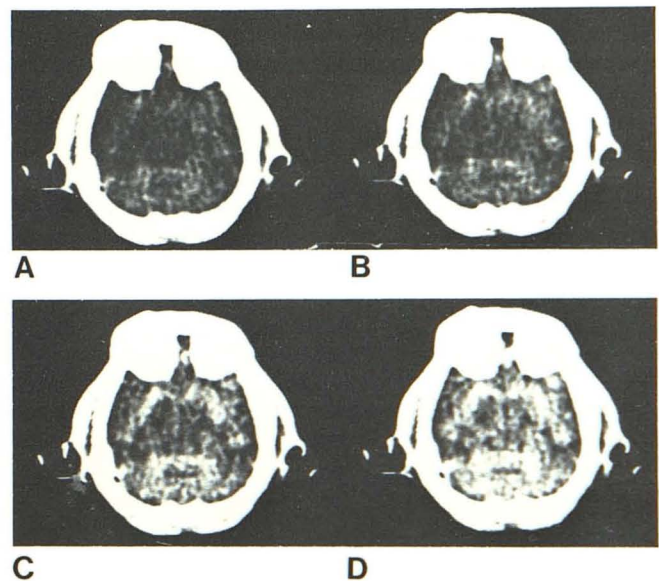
Stable xenon buildup. Serial CT scans in baboon at level of midbrain, cerebellum, and temporal lobe during constant inhalation of 80% xenon. Baseline scan (A) compared with scans 1 (B), 2 (C), and 3 (D) min after initiation of xenon inhalation. Prominent, progressively increasing brain enhancement readily noted.
